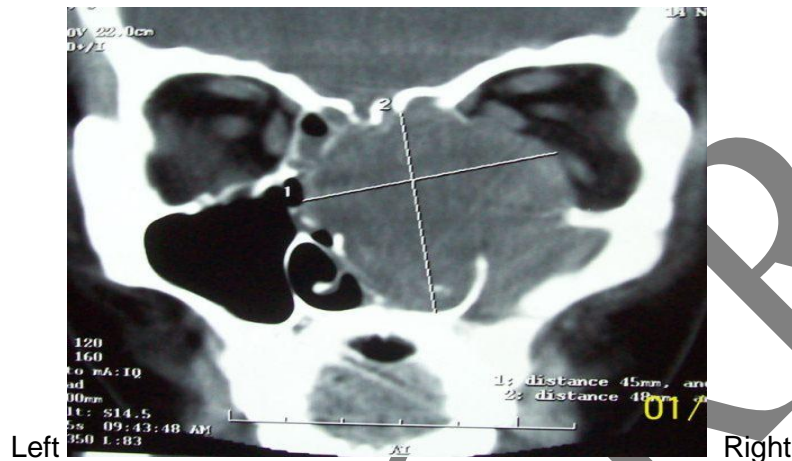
CT Scan of PNS (coronal view) showing large soft tissue mass involving the right nasal cavity, orbit, and pushing the nasal septum to opposite side
